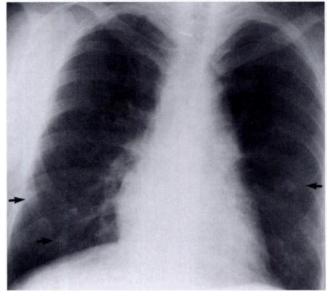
Disseminated MAC infection after renal transplantation in a man who developed a skin infection due to MAC on the dorsum of his foot. Chest radiograph obtained a week later shows a nodular opacity (arrows). Concurrently, he developed multiple cutaneous foci of disseminated infection. Although pathologically unproved, these foci probably represent disseminated infection to the lung.
